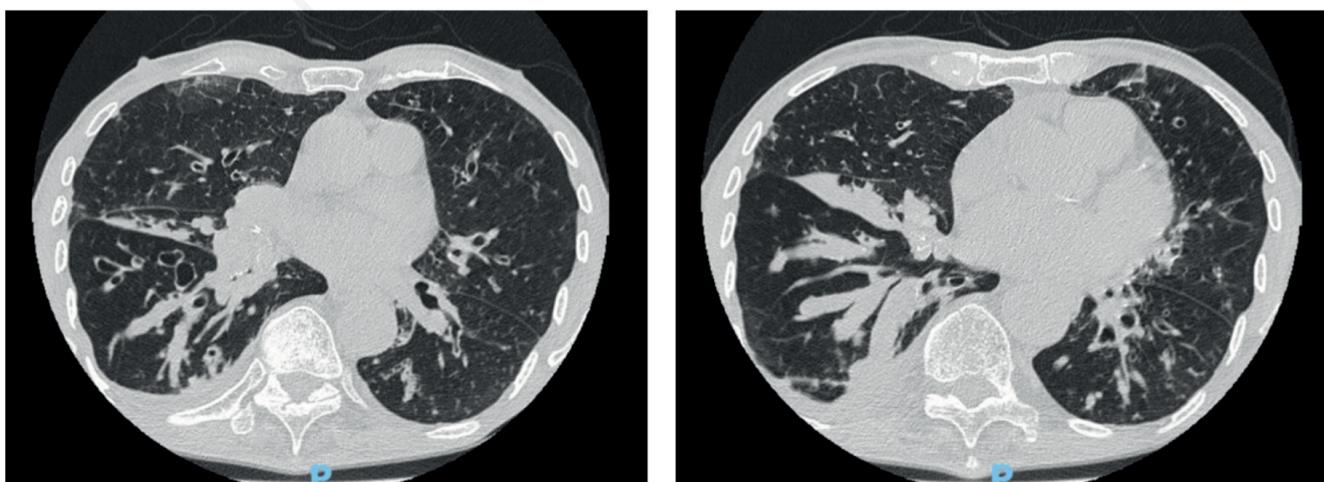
Chest CT scan showing varicose and cystic bronchiectasis with abundant mucous content.
